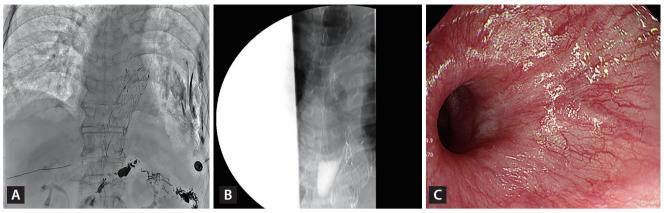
(A) Chest X-ray reveals thoracic endovascular aneurysm repair (TEVAR) with two metallic stent grafts. (B) Esophagography shows a narrow esophageal lumen due to extrinsic compression at insertion site of TEVAR. (C) Esophagogastroduodenoscopy after 2 months shows the mid-esophageal lumen with a slightly dilated diameter.
